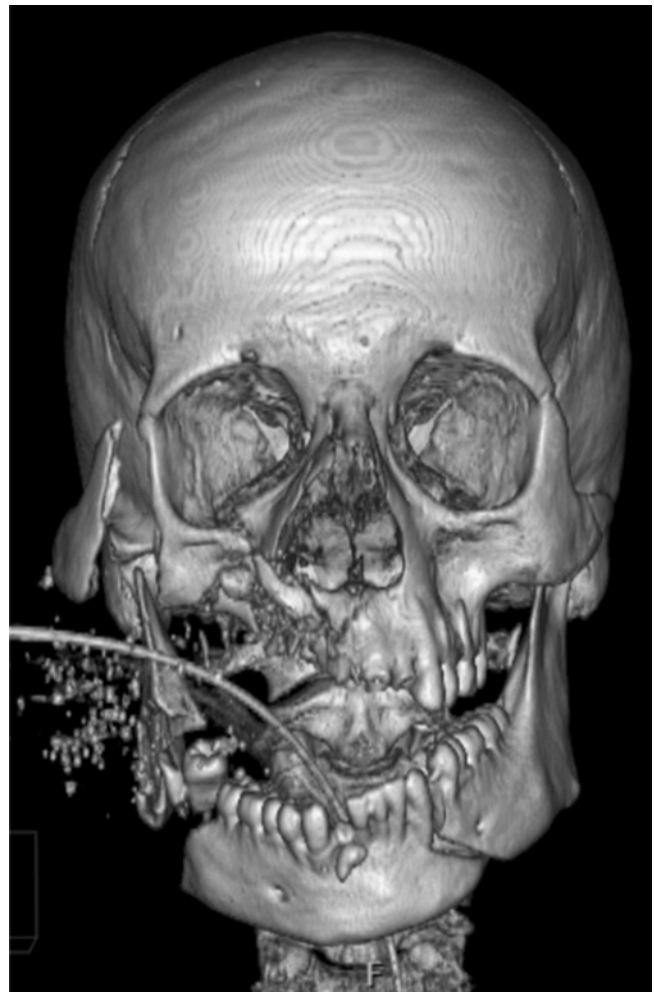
CT scan showing extent of bony injury
